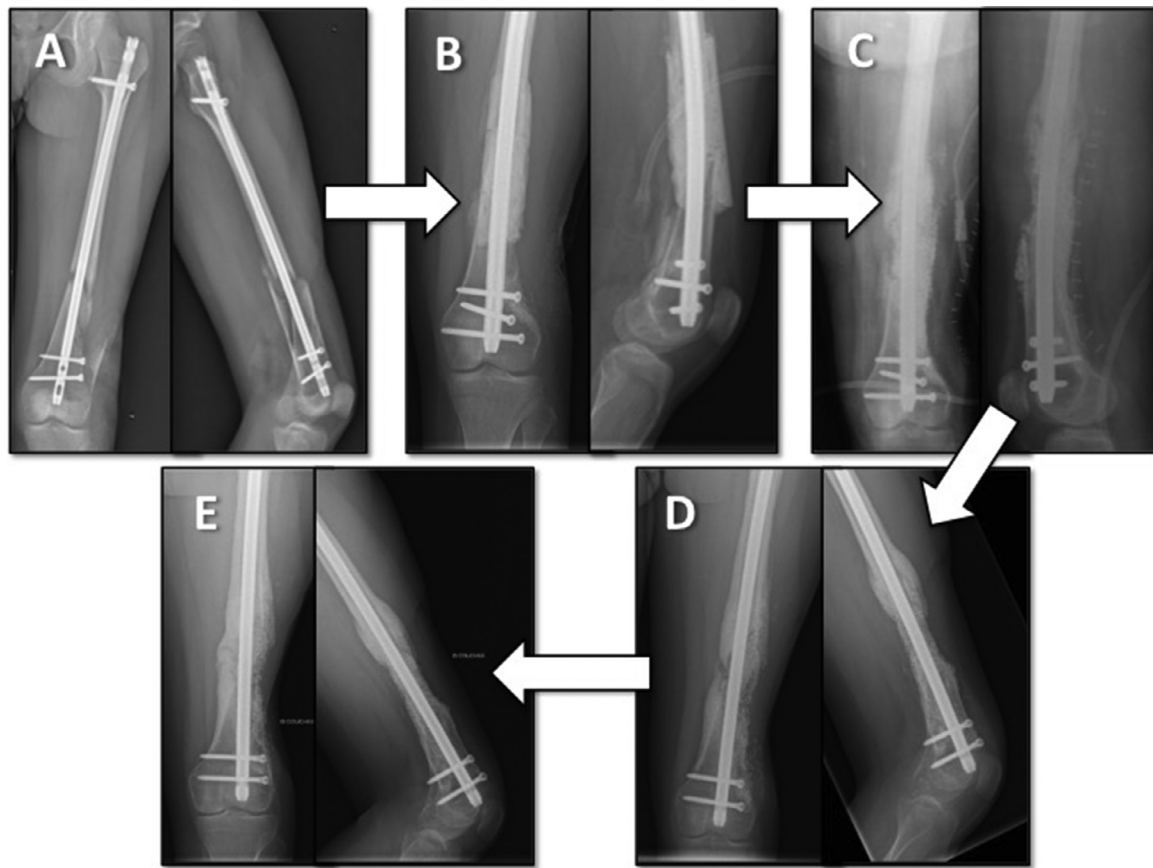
Example of the use of BAG for a third stage of induced membrane technique following a recurrence of the infection after the second stage in a left femoral defect (A: pre-operative X-Rays, B: First stage X-Rays, C: Third stage X-Rays at 11 months, D: X-Rays at 1 year, E: X-Rays at 2 years follow-up).
